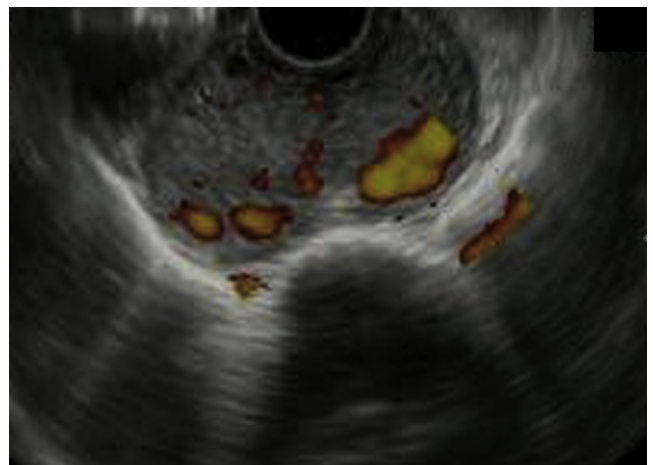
Endosonographic view of mucosal esophageal mass.
